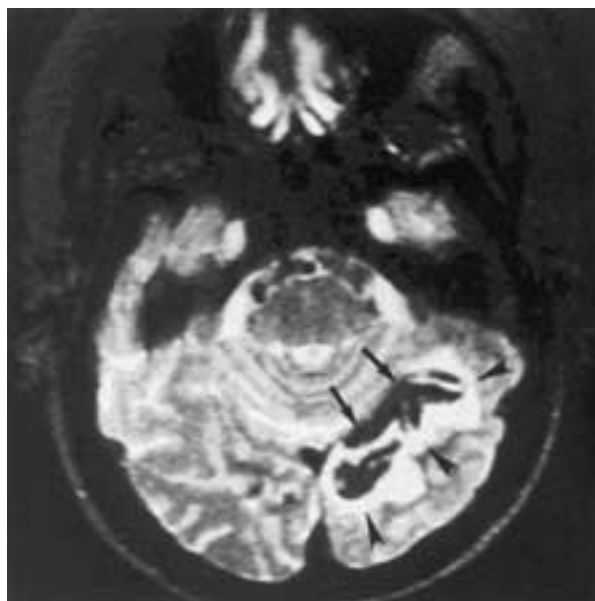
Hemorrhagic infarct. Axial T2-weighted image shows marked hypointensity of deoxyhemoglobin (arrows) in the cortex of portions of a hemorrhagic infarction. Surrounding hyperintensity is present (arrowheads).
